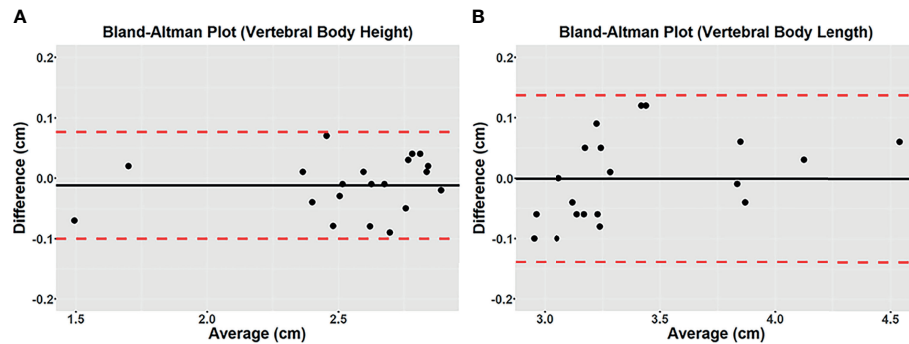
Bland-Altman plots of differences between 3D CT and 3D UTE MRI for vertebral body height (A) and vertebral body length (B) measured on the mid-sagittal plane from the *in vivo* study. A solid line represents the mean of all differences (bias), while a dashed line indicates the 95% interval confidence of agreement. All measurements were within the 95% confidence interval limits.
